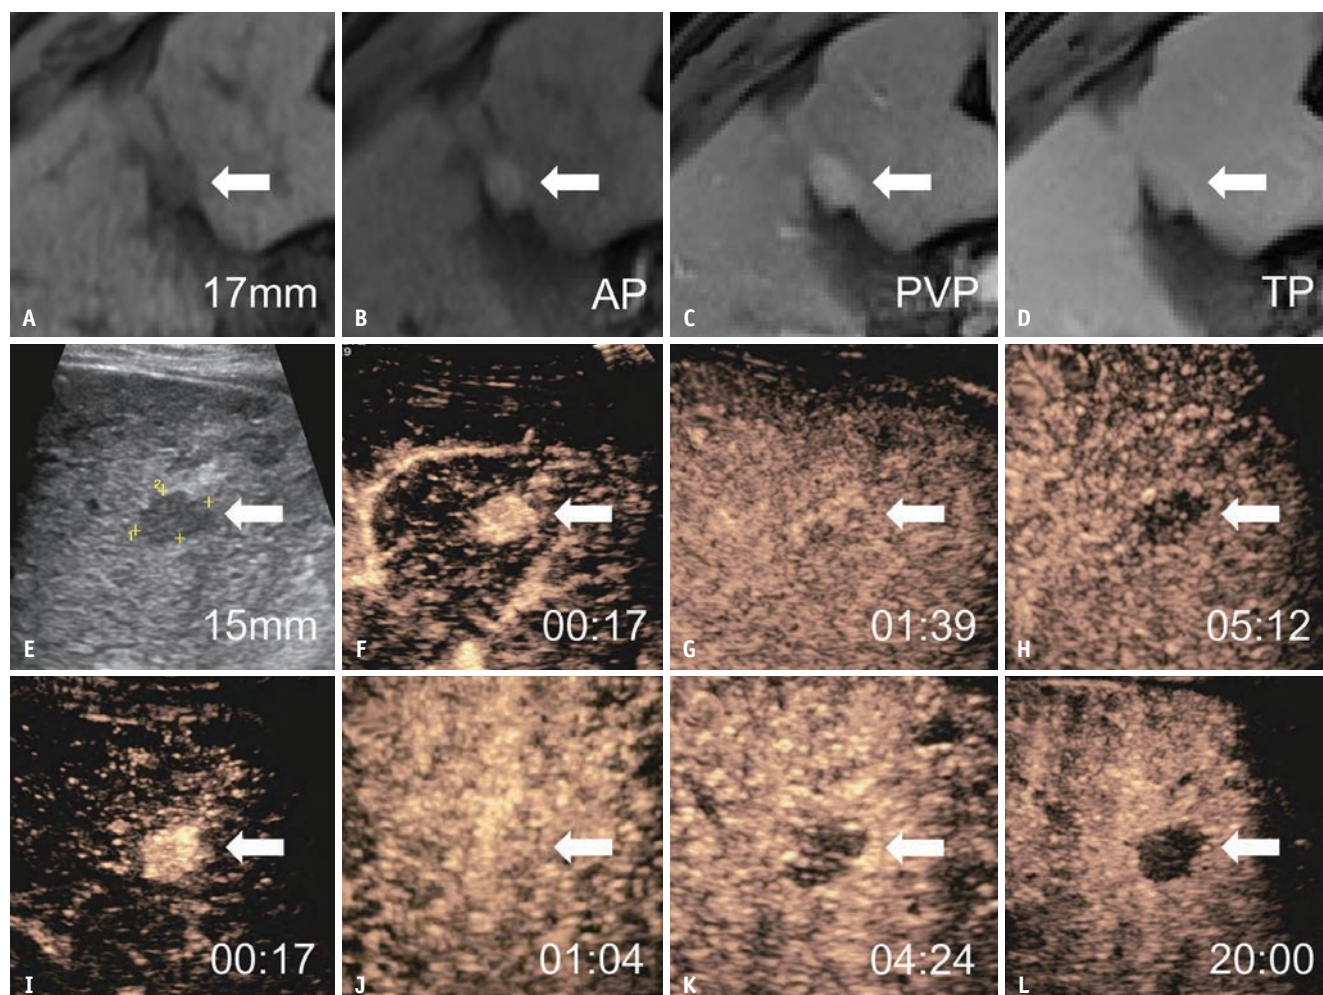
Images of a 52-year-old male at high risk of HCC due to liver cirrhosis caused by chronic hepatitis B virus infection. A: On contrast-enhanced MRI with hepatobiliary agent gadoxetate disodium, T1-weighted image shows a 17 mm hypointense observation in segment IV/V (arrow). B: AP image shows non-rim APHE (arrow). C: PVP image shows the observation without non-peripheral washout (arrow). D: TP image shows the observation without enhancing “capsule” (arrow). E: Gray-scale US image showing a 15 mm hypoechoic observation in segments IV/V (arrow and calipers 1 and 2). F: On SHF-enhanced US, the AP image at 17 seconds shows non-rim APHE (arrow). G: PVP image at 1:39 minutes showing no washout (arrow). H: Late-phase image at 5:12 minutes showing late and mild washout (arrow). I: On PFB-enhanced US, AP image at 17 seconds shows non-rim APHE (arrow). J: PVP image at 1:04 minutes showing no washout (arrow). K: Late-phase image at 4:24 minutes showing late and mild washout (arrow). L: Kupffer-phase image at 20 minutes shows a marked Kupffer defect (arrow). This observation was assigned as LR-3 by CT/MRI LI-RADS and LR-5 according to the following criteria: LI-RADS SHF, LI-RADS PFB, and modified PFB. The pathological diagnosis based on the needle biopsy was HCC. HCC = hepatocellular carcinoma, AP = arterial phase, APHE = arterial hyperenhancement, PVP = portal venous-phase, TP = transitional-phase, US = ultrasound, SHF = sulfur hexafluoride, PFB = perfluorobutane, LI-RADS = Liver Imaging Reporting and Data System
